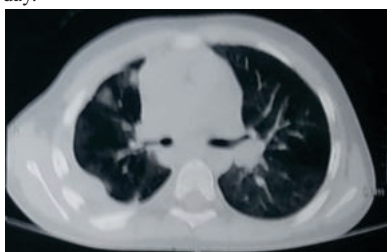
FIG - HRCT Chest reveals minimal right pleural effusion with nodular
